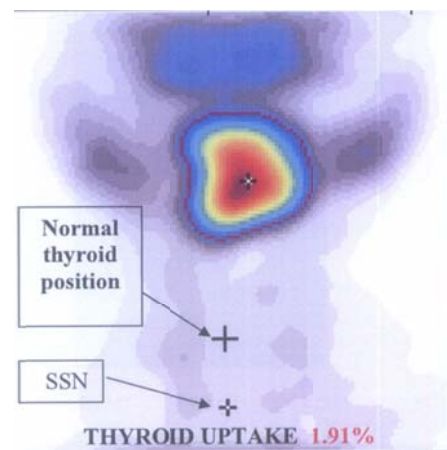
Thyroid scintigraphy showing absent normal thyroid gland and instead radioactive thyroid tissue noted in the sublingual region as an ectopic thyroid gland with two markers (+) one at ectopic region and another one at the suprasternal notch (SSN) and also showing normal thyroid radiotracer uptake (1.91%).
